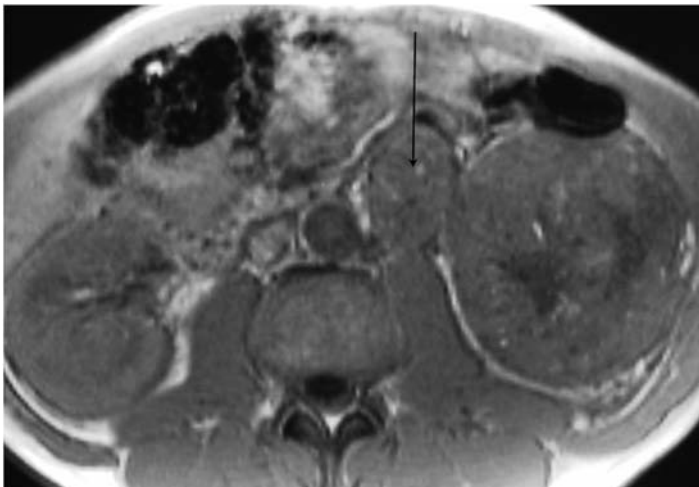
Magnetic resonance imaging demonstrates a large left-sided para-aortic lymph node mass (arrow). Magnetic resonance imaging was performed in preference to CT in this patient because of a previous reaction to iodinated contrast but in general MRI does not provide any supplementary information to CT for most cases of renal cancer.
